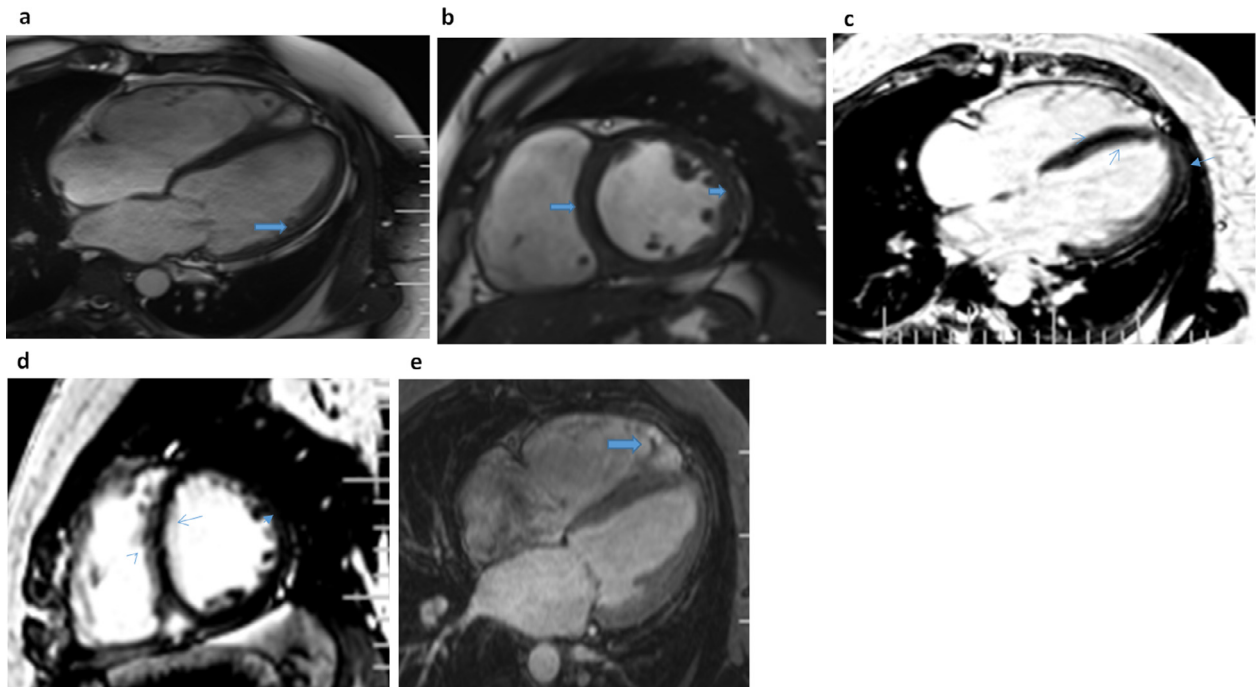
Post-COVID myocarditis. 34-year male, diagnosed with COVID-19 2 months' back. Persistent fatigue and breathlessness after recovery from COVID. RT-PCR negative. On 2D echo- RV and LV were dilated. Cardiac MRI was performed. (A,B): Fast spin echo (FSE) T2-W images (A) four chamber, (B) two chamber short axis view reveal dilated LV, RV and myocardial edema (arrows) (C,D) LGE (Late gadolinium enhancement) PSIR (phase sensitive inversion recovery) images, (C) four chamber, (D) two chamber short axis view: showing diffuse epimyocardial and midmyocardial linear enhancement predominantly along the septum and lateral wall (thin arrows in C & D). (E) Inversion recovery (IR) thrombus imaging: small thrombus in the RV apex (thick arrow). Global systolic dysfunction with LVEF of 43% was also noted. (Color version of figure is available online).
